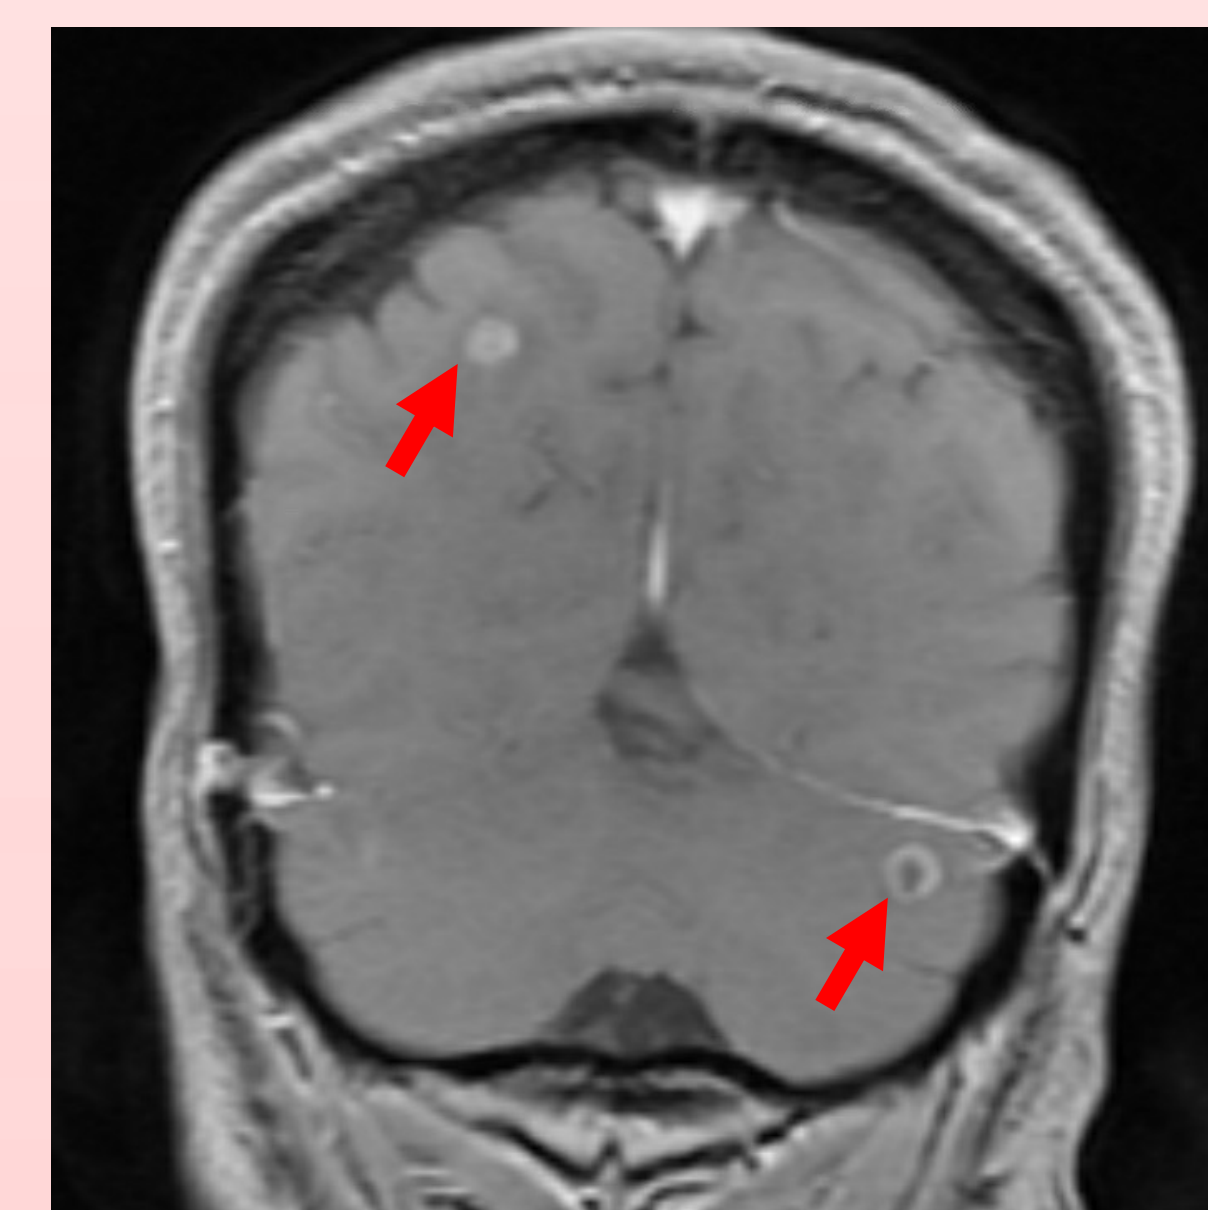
MRI showing metastatic lesions in the cerebrum and cerebellum (red arrows).
